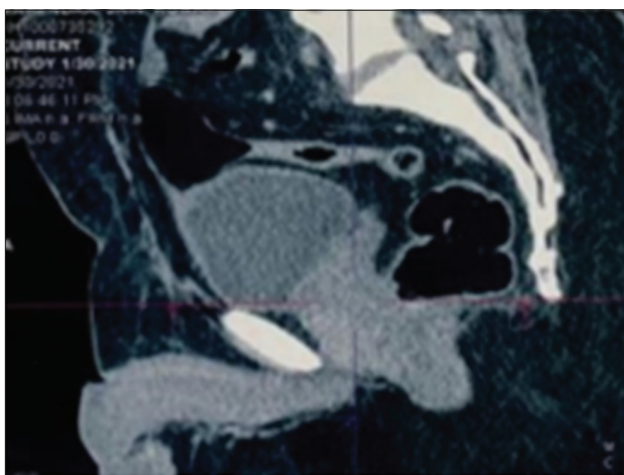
CT scan shows enlarged prostate with lesion infiltrating root of seminal vesicles and neck of urinary bladder.
